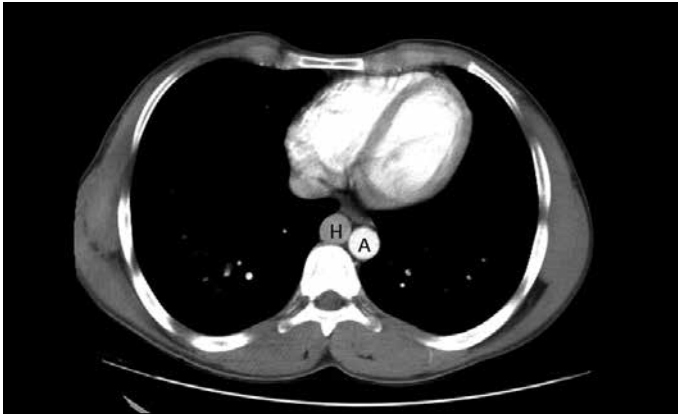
Abdominal axial computed tomography (CT) examination of the patient. This abdominal CT image shows hemiazygos continuation (H) beside the aorta (A)
